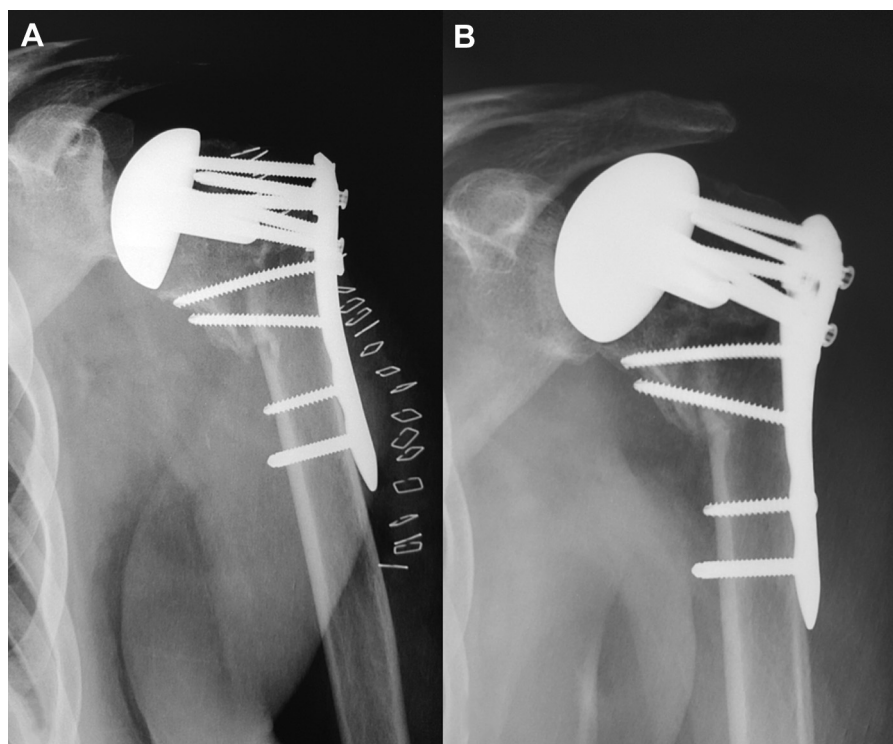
Immediate postoperative radiograph (A) and a radiograph showing the healing of the fracture (B).
